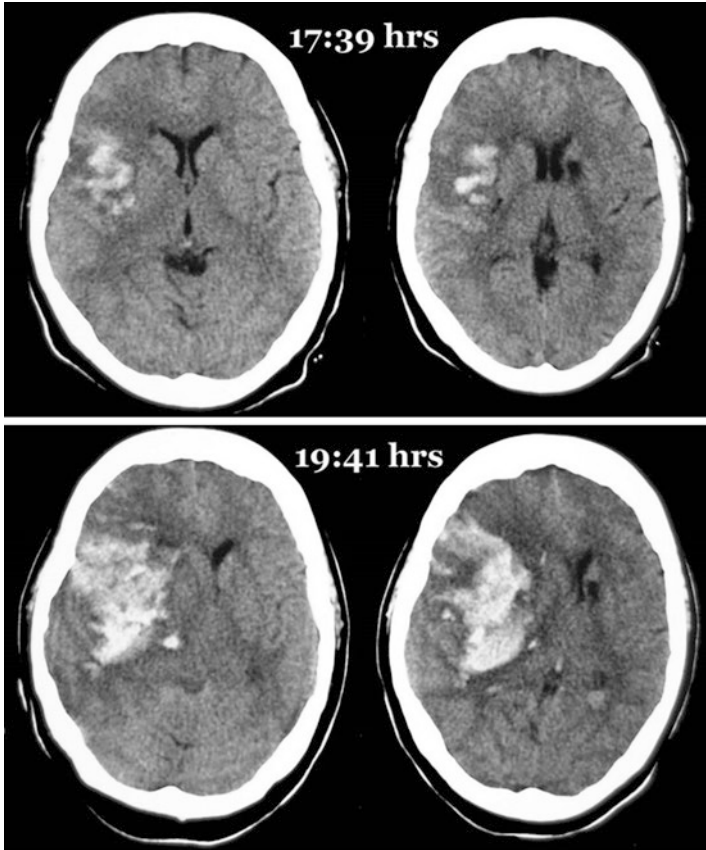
Non-contrast CT scan of a 60-year-old lady with sudden left hemiplegia who had thrombolysis. Immediate CT scan prior to thrombolysis was unremarkable (not shown). Six hours following thrombolysis the CT scan at 17:39 h was obtained for increased drowsiness. Two hours later, large increase in the size of the clot is evident, *this hemorrhagic conversion can occur with or without thrombolysis*
